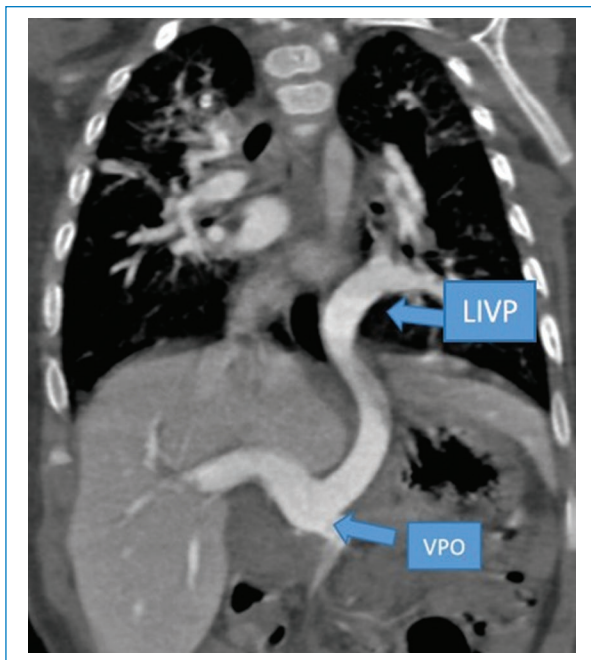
Magnification of a thoracic CT angiogram in an oblique coronal slice, mediastinal window where it is possible to visualize the drainage of the left inferior pulmonary vein (LIPV) into the portal vein (VPO), the same that appears with its caliber increased (*source: WebDiagRX institutional electronic storage system*).
